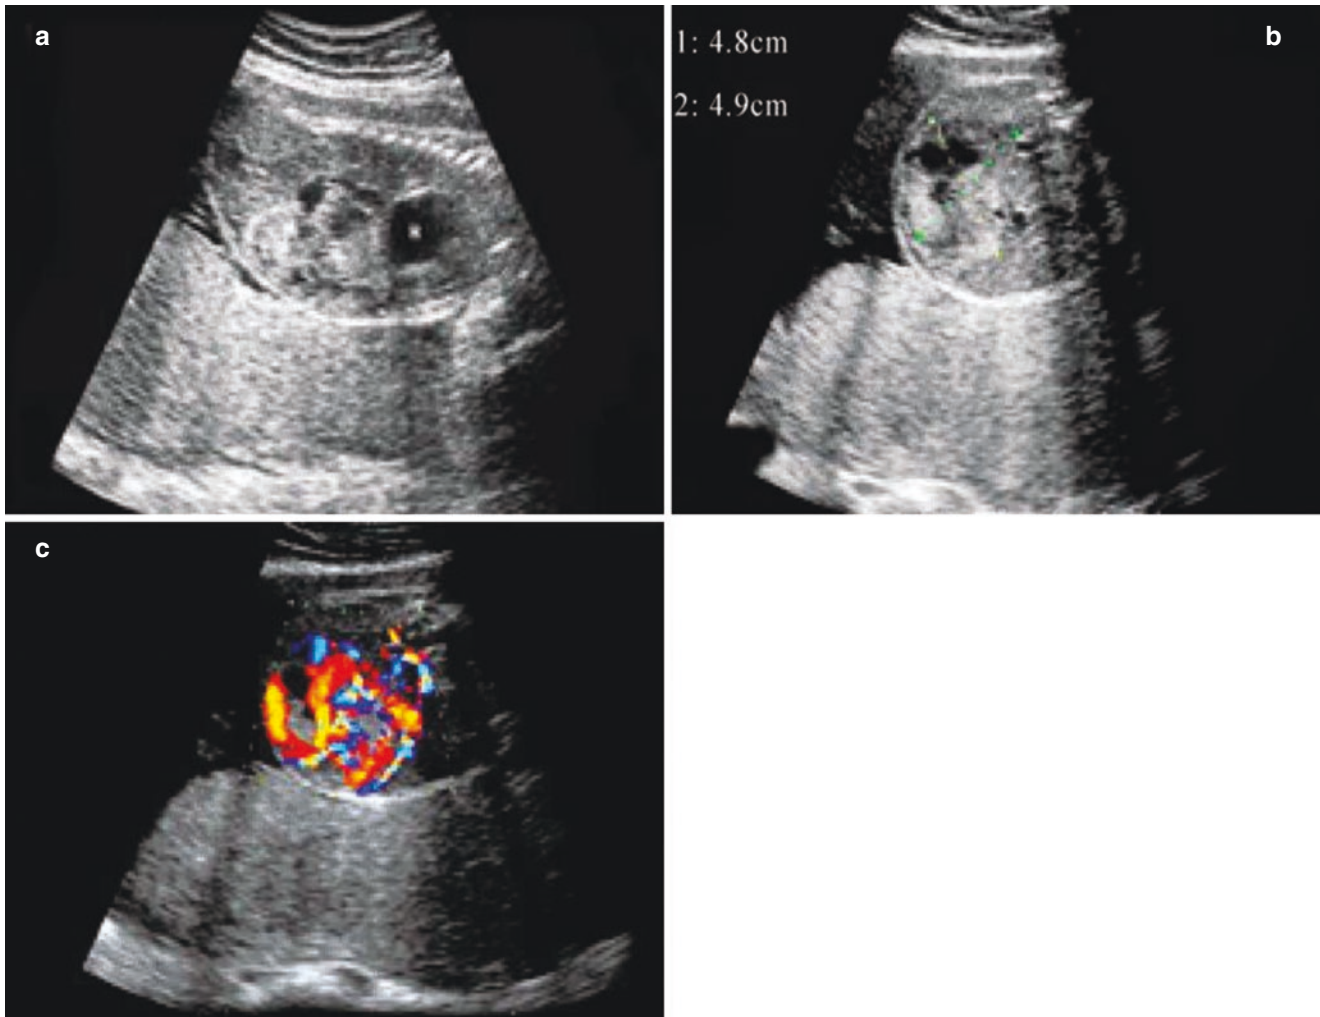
Liver tumor. At 26 weeks of gestation, the ultrasound revealed a solid lesion in the liver with a diameter of about 5.0 cm. (a). The sagittal view of the liver tumor. (b). The transverse view of the liver tumor. (c). CDFI shows the blood flow in the mass
